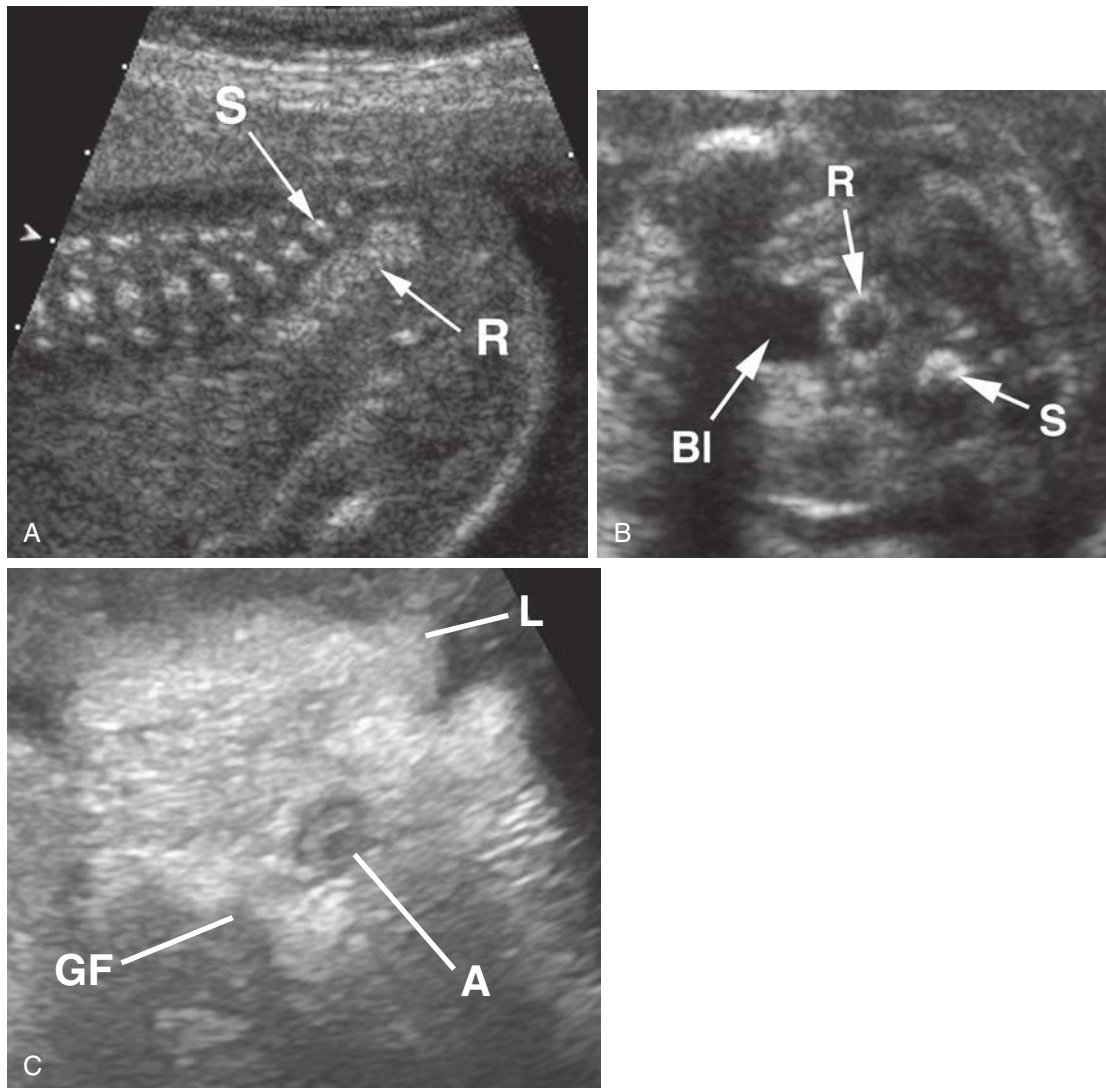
A, Midsagittal sonogram demonstrates the rectum (R) anterior to the sacrum (S). B, A transverse axial sonogram demonstrates the rectum (R) lying between the bladder (Bl) and sacrum (S). C, Transverse axial sonogram demonstrates the anus (A). GF, gluteal fold, L, labia majora.
